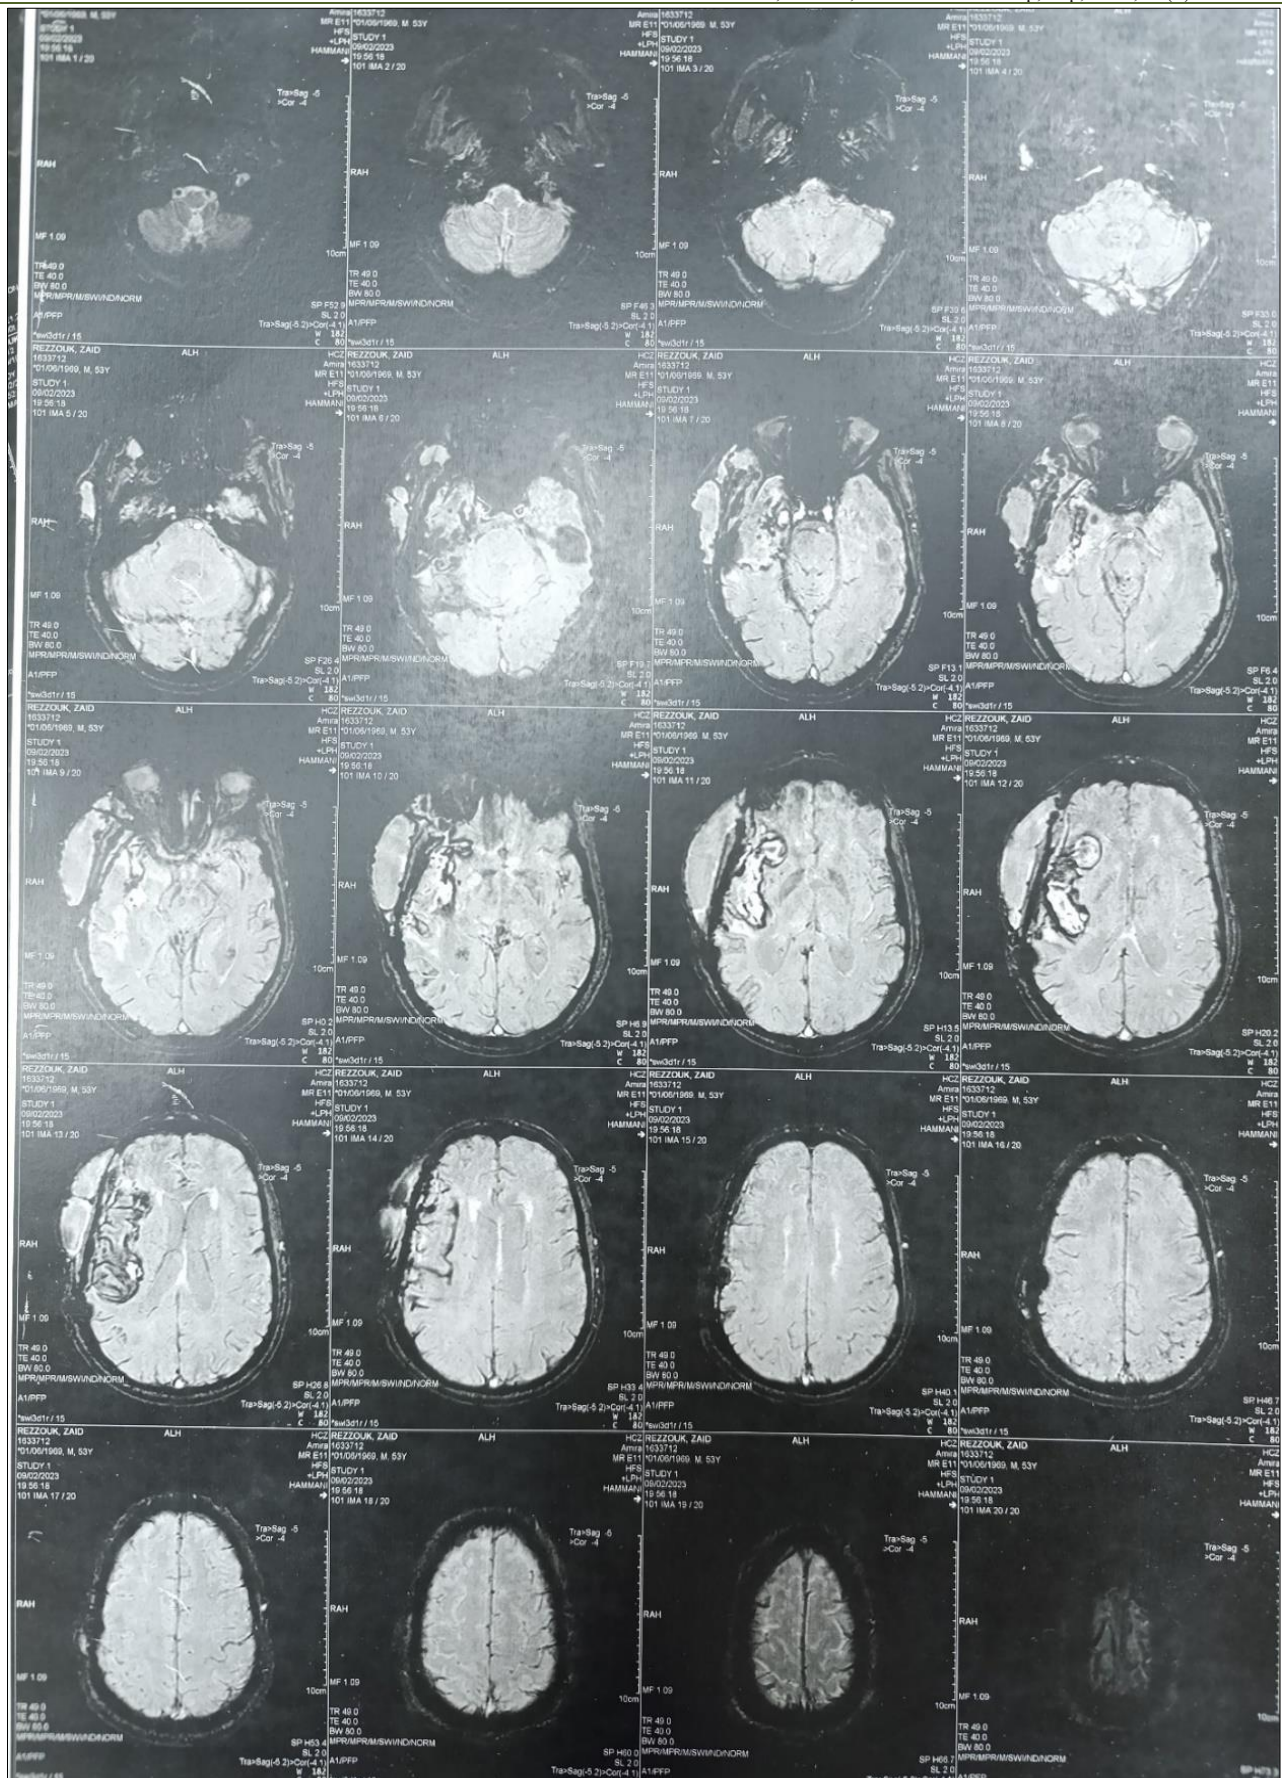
Early postoperative MRI in axial sections. Showing a tumor remnant with a right temporal porencephalic cavity
